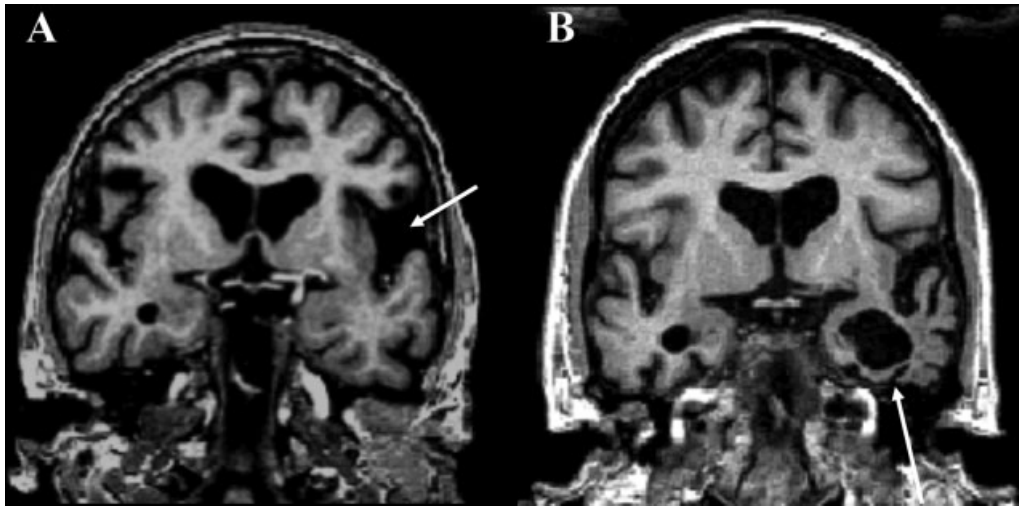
Coronal T1-weighted MRI in patients with primary progressive aphasia (PPA). (A) nfvPPA in a 66-year-old woman, MMSE: 28. Left predominant atrophy of the operculum is evident (arrow). (B) svPPA in a 66-year-old man with MMSE: 26. Atrophy is most prominent in the left perisylvian region, including the medial temporal lobes (arrow). Adapted with permission from Vitali P, Migliaccio R, Agosta F, Rosen H, Geschwind M. Neuroimaging in dementia. *Semin Neurol* 2008;28(4):467–483.
